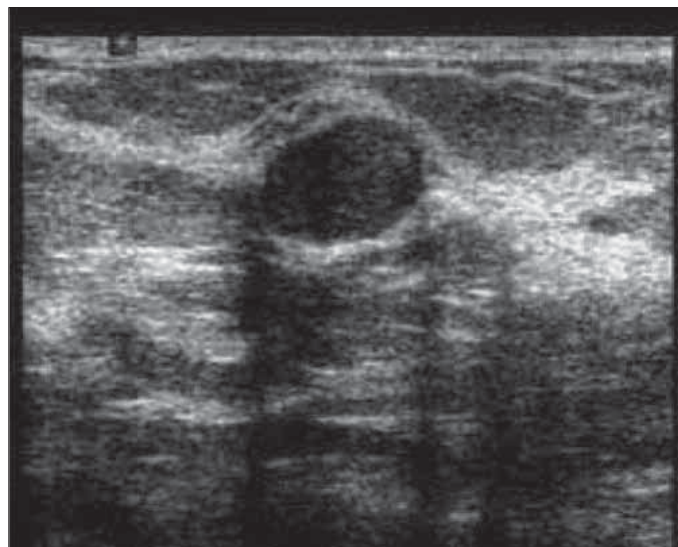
Image of breast ultrasonography
